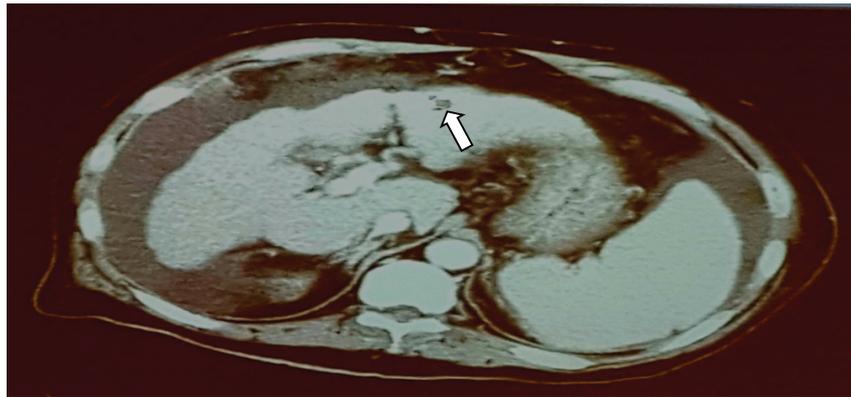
Contrast-enhanced CT scan image of small HCC nodule in cirrhotic liver.
